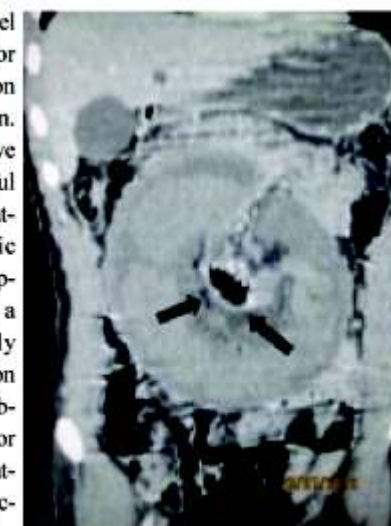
Coronal reconstruction CT image showing extensive small bowel intussusception. Mesentery along with fat layers is seen clearly (arrows)
